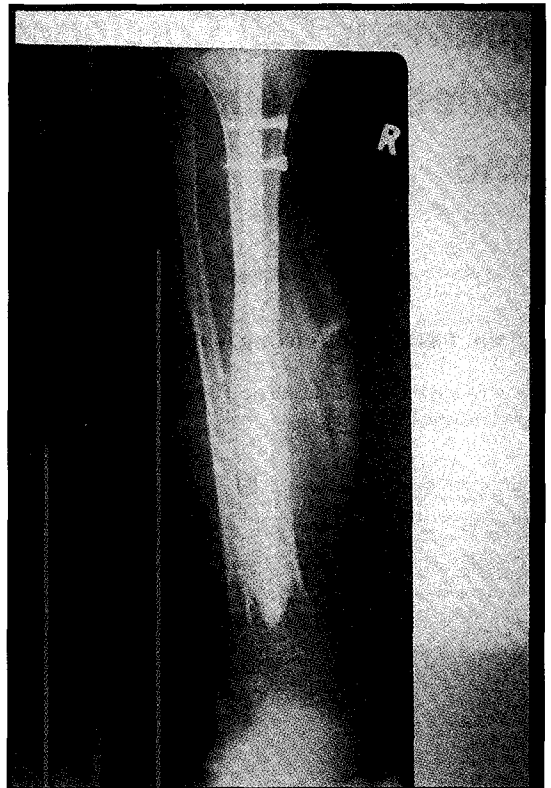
Plain x-rays showing the reimplanted bone stabilized with an interlocking nail and bone cement
